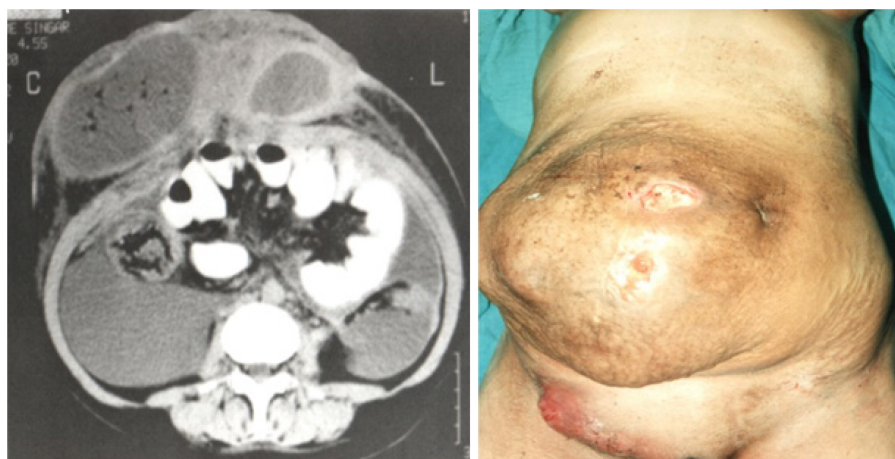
Computed tomography view of omental strangulation and necrosis findings in our patient who underwent laparotomy due to strangulated incisional hernia and right femoral hernia.
